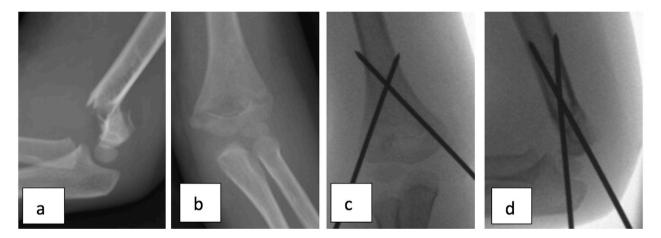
(a, b) Pre-operative AP and lateral radiograph showing type IIb fracture. (c, d) Intraoperative AP and lateral radiograph showing adequate reduction and fixation with crossed K- wire
